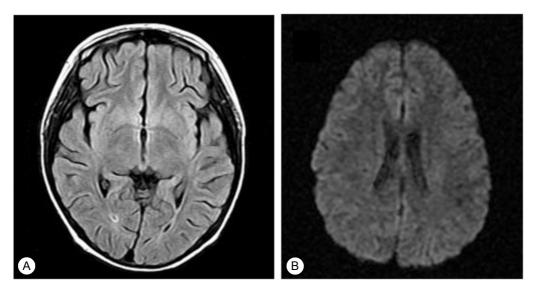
Follow up fluid attenuated inversion recovery magnetic resonance imaging (MRI) 5 days later showed resolution of the previous lesions (A), and on diffusion-weighted MRI (B).
